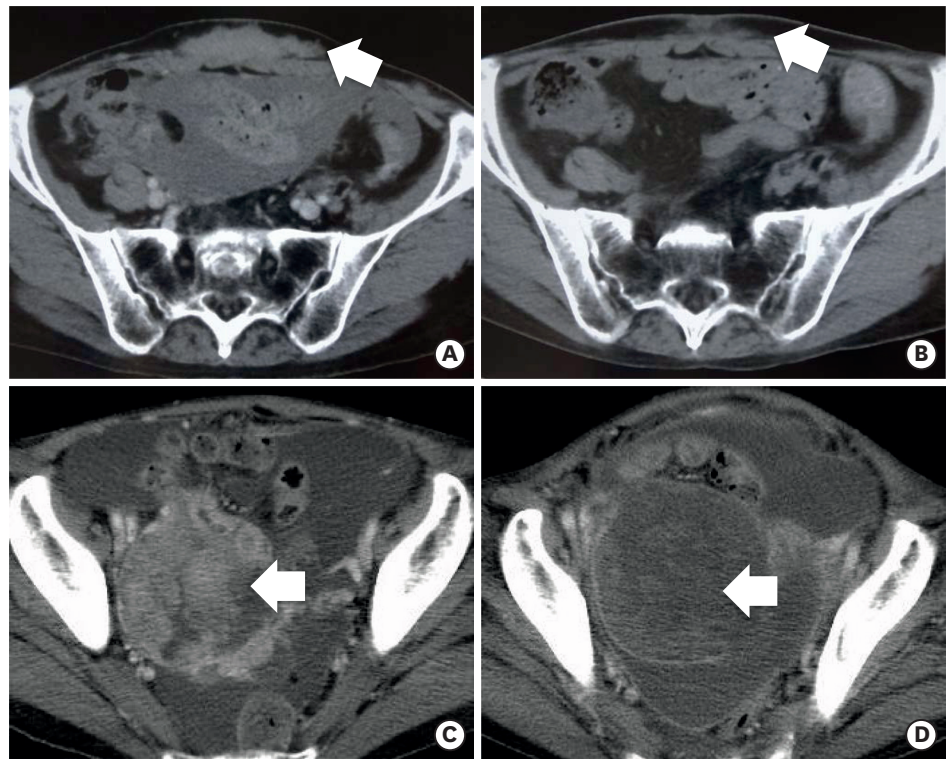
Contrast-enhanced CT images showing pre (A, C) and post (B, D) pazopanib treatment. White arrows indicate target lesions. (A, B) Case 6: CS of the uterus, reduction of abdominal tumors and malignant ascites were observed after 51 days of pazopanib oral intake. (C, D) Case 7: CS of the ovary, reduction of the solid components of ovarian tumor and malignant ascites were observed after 40 days of pazopanib oral intake. CS, carcinosarcoma; CT, computed tomography.
